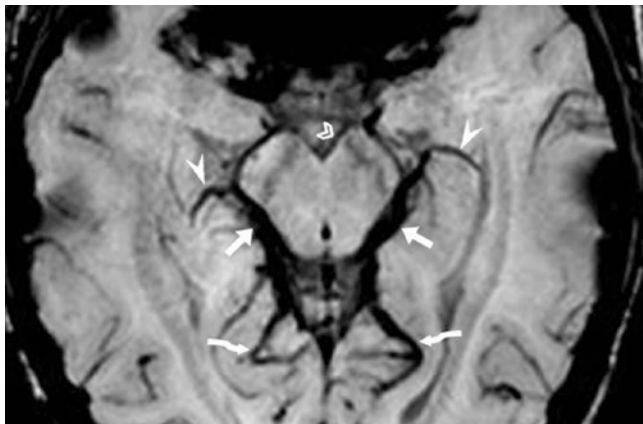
A 3 T MRI in a 14-year-old. 10 mm thickness SWI shows the BVRs (*short arrows*), asymmetry of the IVVs (*arrowheads*), a dominant left IOVs (*curved arrows*), and a small left interpeduncular vein (*chevron*). The deep MCVs are obscured by artifact from gas in the sphenoid sinus
